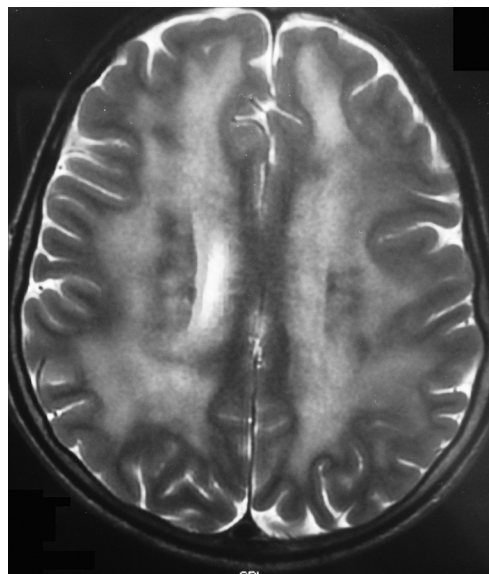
T2-weighted brain magnetic resonance imaging showed increased signal, affecting the subcortical and periventricular white matter of the both hemispheres.
